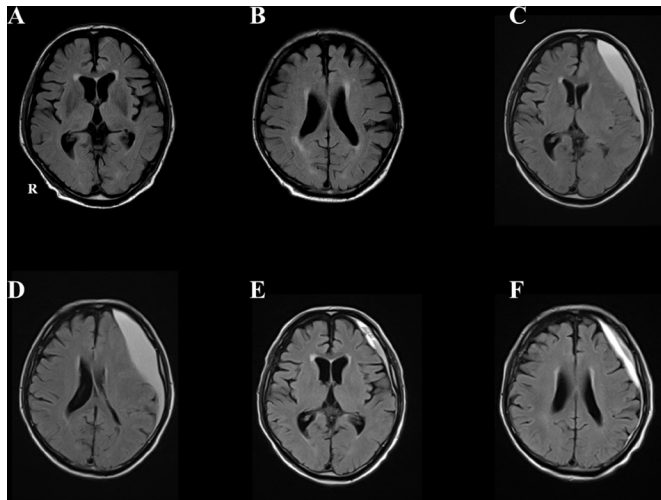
(A, B) Axial fluid-attenuated inversion recovery (FLAIR) images carried out immediately after the head trauma showing no structural lesions in basal ganglia and cerebral cortices. (C, D) Presurgical FLAIR images showing large subdural haematoma in the left convexity with marked compression of the left hemisphere. (E, F) FLAIR images carried out 4 weeks after his operation showing improvement of haematoma.
